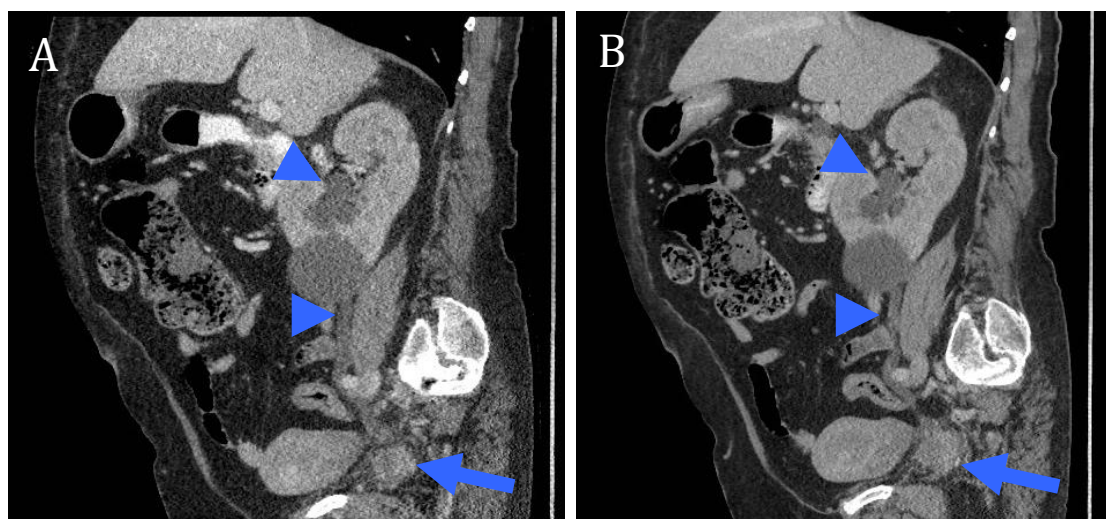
Modified (A) and conventional (B) dose sagittal CT reconstructions of the abdomen and pelvis demonstrating a tumour of the cervix (blue arrow) in a 73 year old woman with a BMI of 31.4kg/m². The arrow heads indicate associated hydroureter and hydronephrosis secondary to the tumour. The effective doses of the modified and conventional dose acquisitions are 4.4mSv and 17mSv, respectively.
